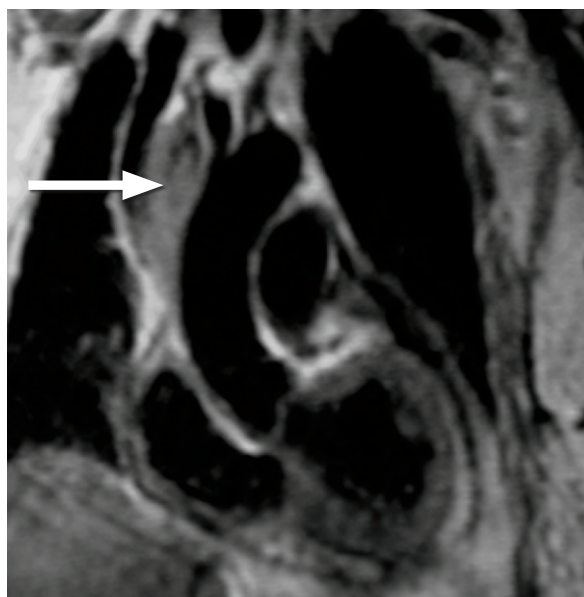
Patient 2. Chest magnetic resonance image shows a pseudoaneurysm of the ascending aorta (arrow).
